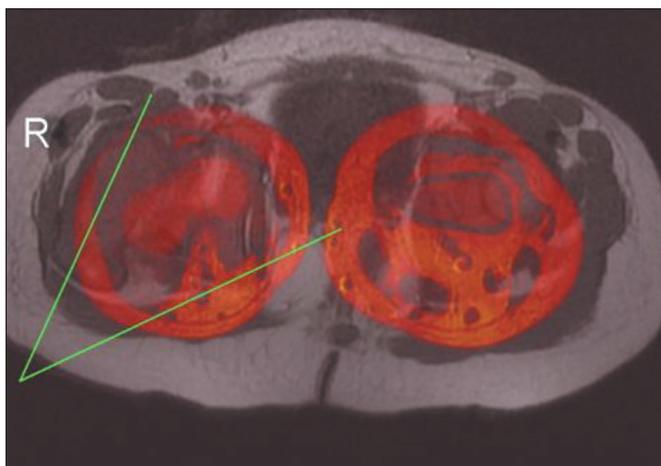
Fused axial T1-weighted FSE MRI sequence showing the lines employed for the measurement of FA in a dysplastic right hip (R). The femoral condyles on the right side are at the same level as the lower femoral diaphysis on the left side, due to superior displacement of the dislocated femur on the right (dysplastic) side.
